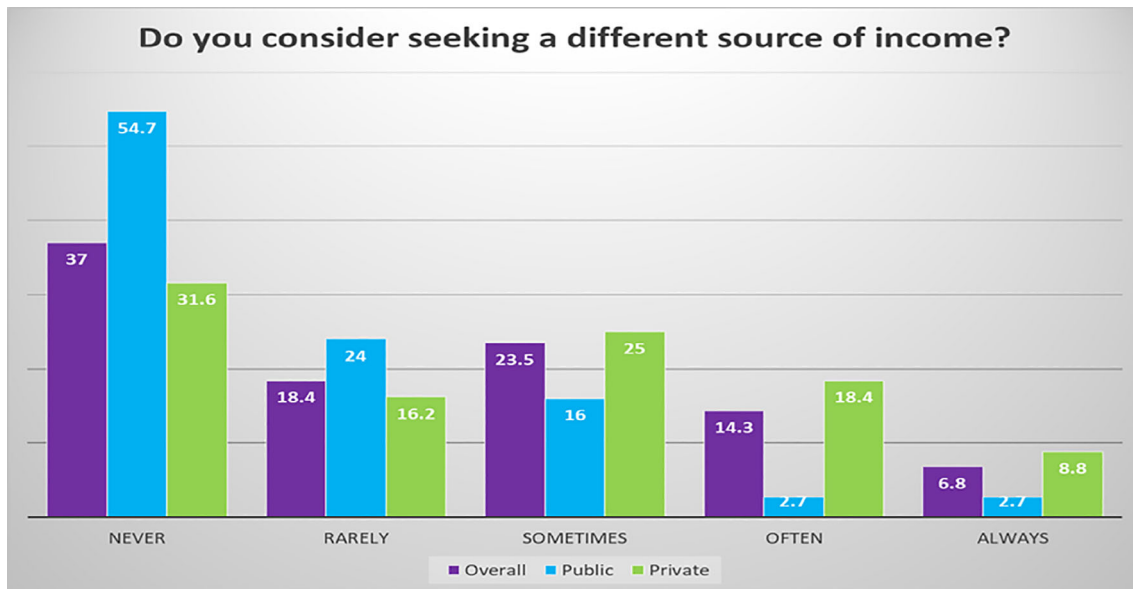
Overall, public hospital, and private practice proportions of sonographers who considered seeking a different source of income
